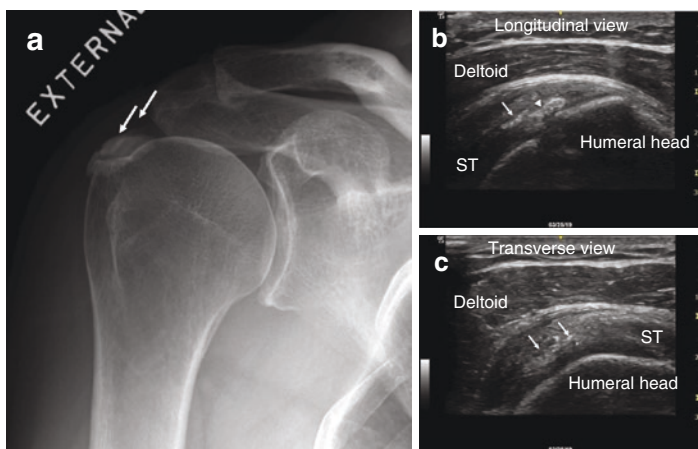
Case 5. (a) Conventional radiography of the right shoulder showing calcific tendonitis. (b, c) Point-of-care ultrasound of the supraspinatus tendon on both longitudinal (b) and transverse (c) views showing hyperechoic aggregates (arrows) and thicker aggregates with posterior acoustic shadowing (arrowhead) consistent with calcific tendonitis of the rotator cuff tendon
